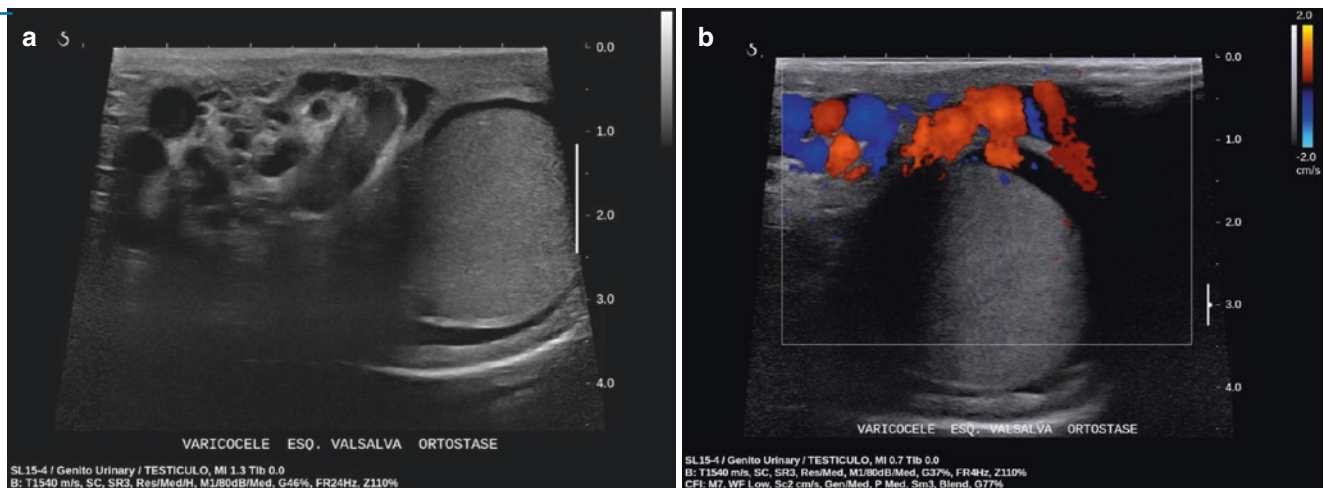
Varicocele Grade 3. (a) B mode ultrasound shows enlarged veins in the upper pole and in front of the testicle only in standing position. (b) Color Doppler shows reflux in the pampiniform vein during Valsalva
